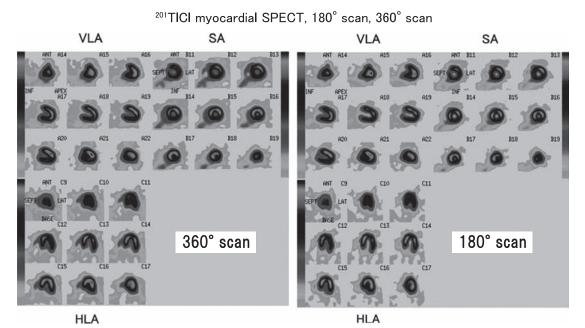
SPECT images of a normal volunteer acquired by 180° and 360° scan
